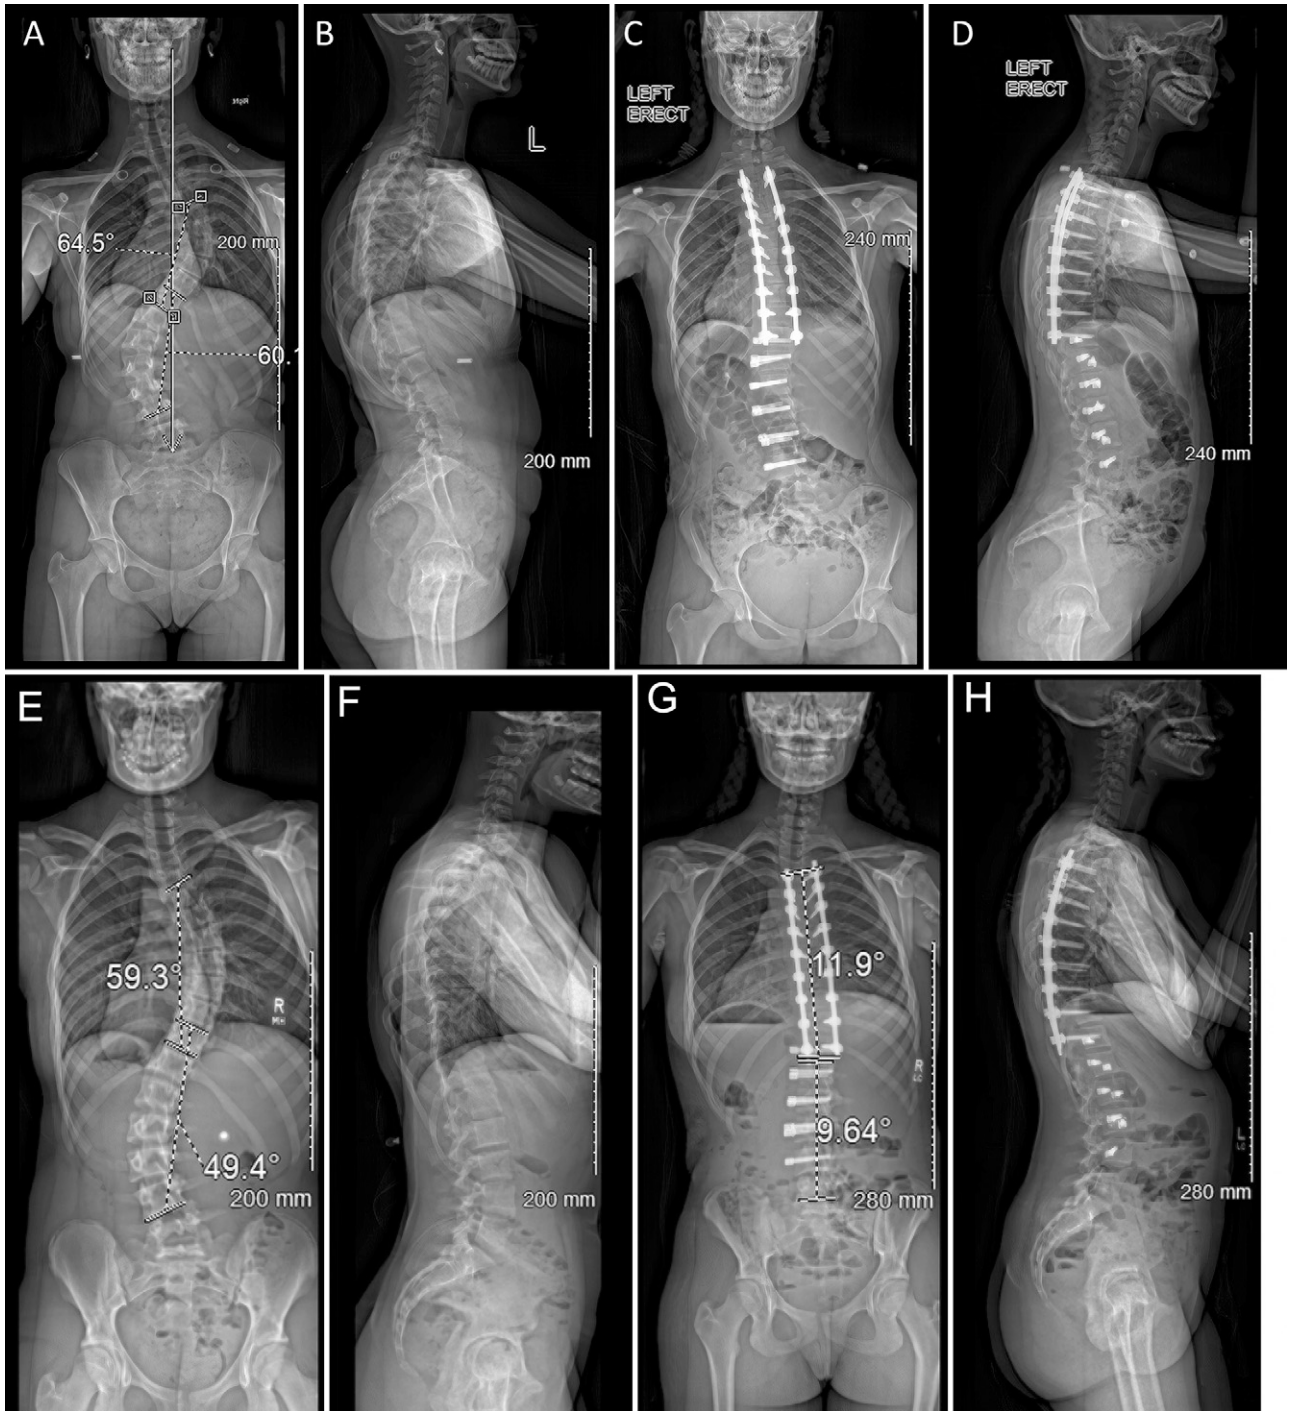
Posteroanterior (PA; A) and lateral (B) radiographs obtained in a 14-year-old girl with AIS who presented with a Lenke 3C double major curve. PA (C) and lateral (D) radiographs obtained after the girl underwent a staged T3–11 PSF and T11–L4 AVBT. PA (E) and lateral (F) radiographs obtained in a 10-year-old girl with AIS who presented with a Lenke 3C double major curve. PA (G) and lateral (H) radiographs obtained after the girl underwent a staged T4–12 PSF and T12–L4 AVBT.
